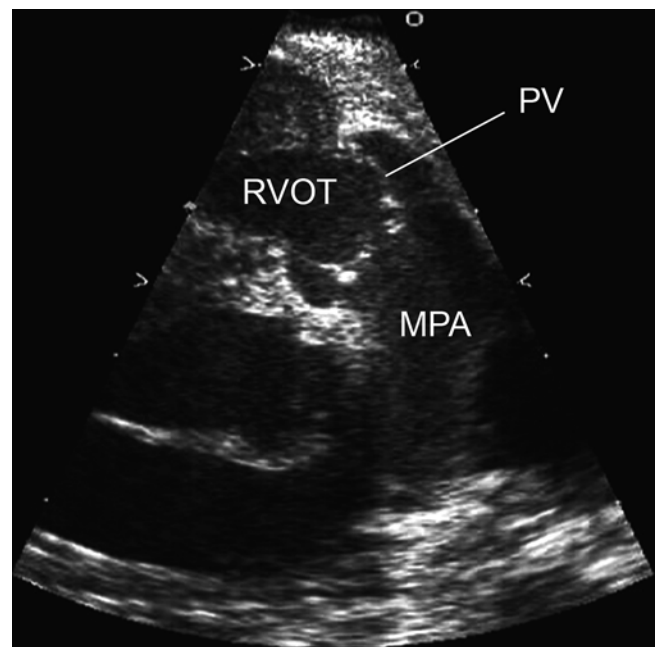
Two-dimensional echocardiogram demonstrating the thickened doming leaflets in a neonate with pulmonary valve stenosis. *MPA* main pulmonary artery, *PV* pulmonary valve, *RVOT* right ventricular outflow tract
